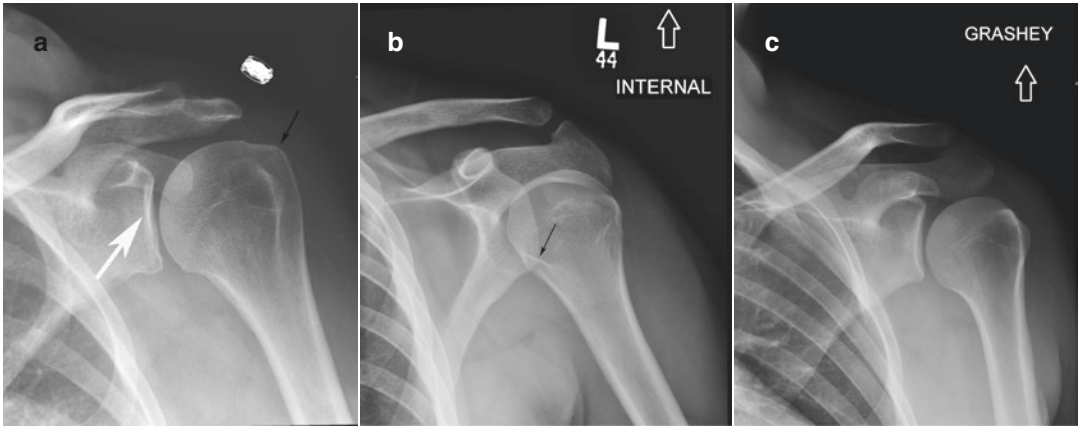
Normal shoulder anatomy. (a) AP externally rotated radiograph of the left shoulder shows the greater tuberosity (black arrow) and pear-shaped articular glenoid fossa (white arrow). (b) AP internally rotated radiograph
